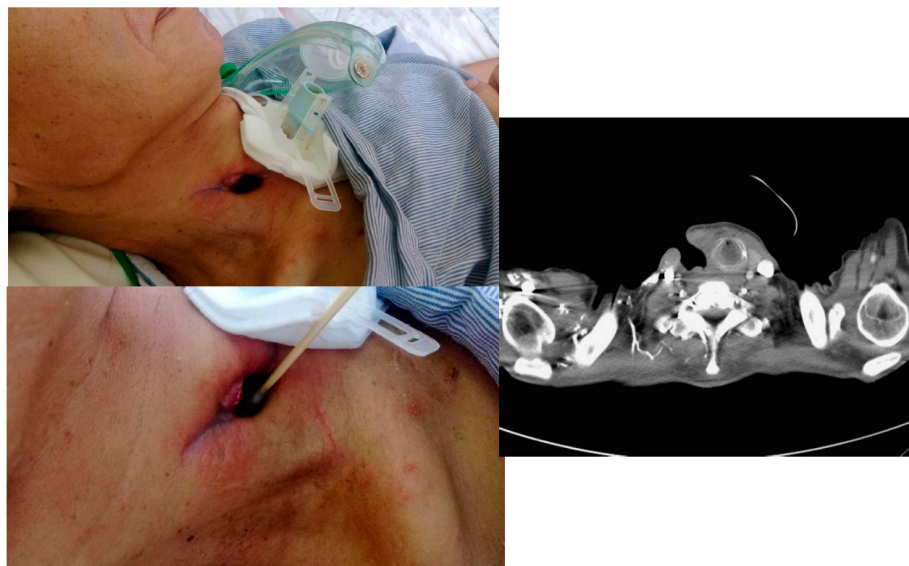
Clinical presentation and CT (computed tomography) scan image after tracheoplasty of case 1. CT scan also demonstrated a residual tumor-cutaneous fistula.
